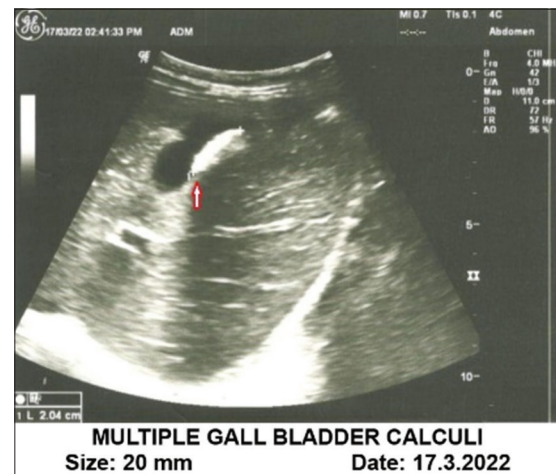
Ultrasonography findings before treatment
